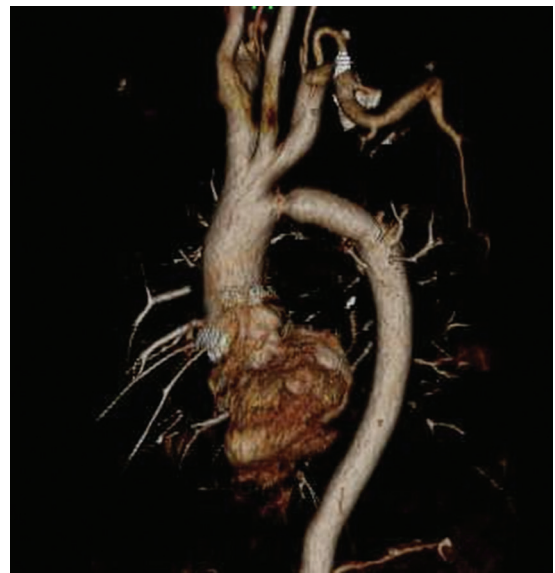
Postoperative three-dimensional computed tomography (3D-CT). The graft is anastomosed to proximal border of the fifth aortic arch, which is not a definitive arch. Although proximal site of the graft anastomosis is slightly stenotic, there is no significant difference in blood pressure between the upper and lower extremities.
